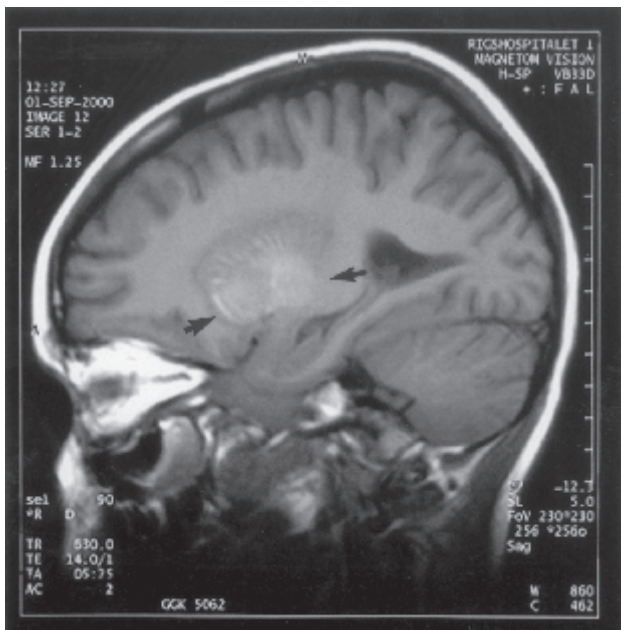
MRI, saggital non-enhanced T1-weighted image 10 days after the onset of neurological symptoms, demonstrating secondary haemorrhage in the infarction (arrows).
